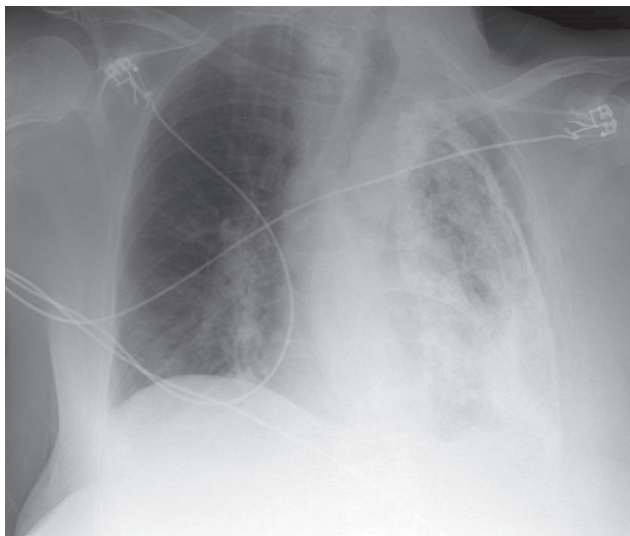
Chest radiograph shows nearly complete left pleural calcification and marked lung volume reduction
